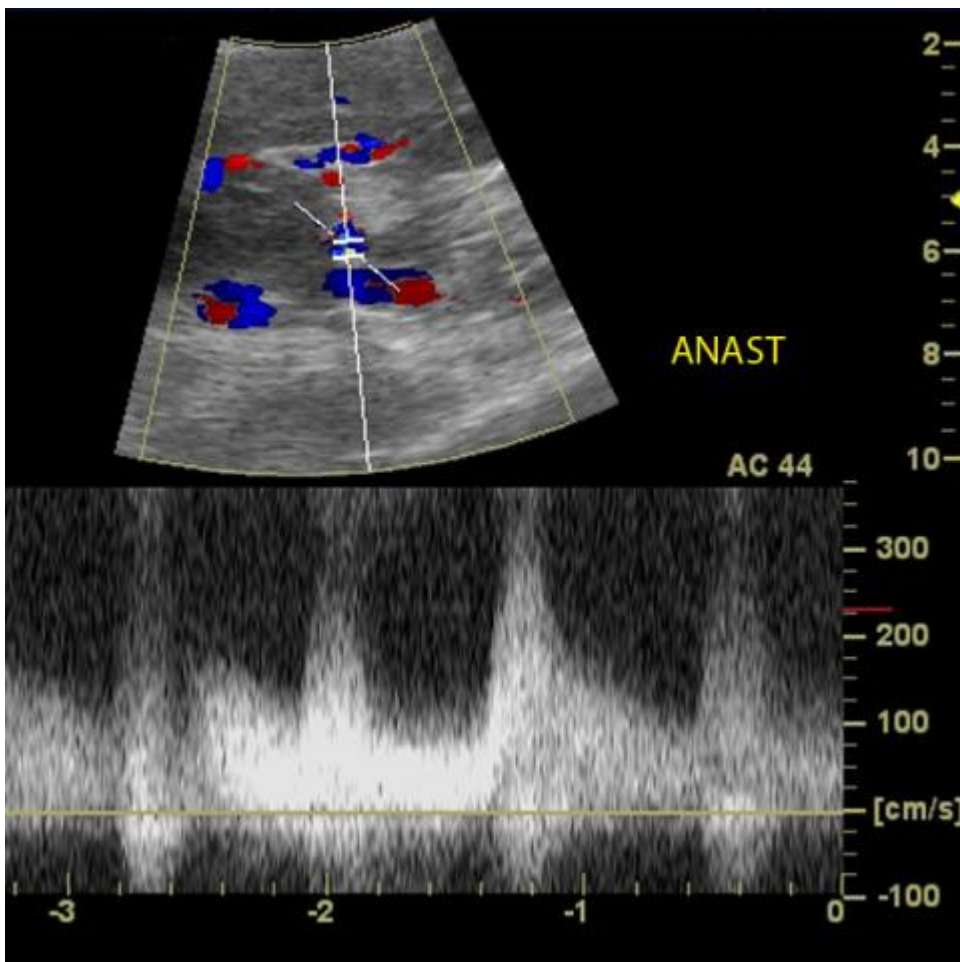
Arterial anastomotic stenosis c) Maximum intensity projection MR image shows focal stenosis (arrow) at the arterial anastomosis.
